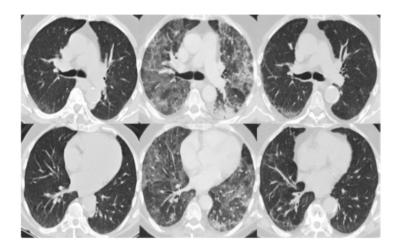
Case two CT scan's evolution .CT of the lungs prior to treatment with rituximab (left panel), during treatment with rituximab (middle panel), and after interruption of rituximab and initiation of corticoids treatment.
